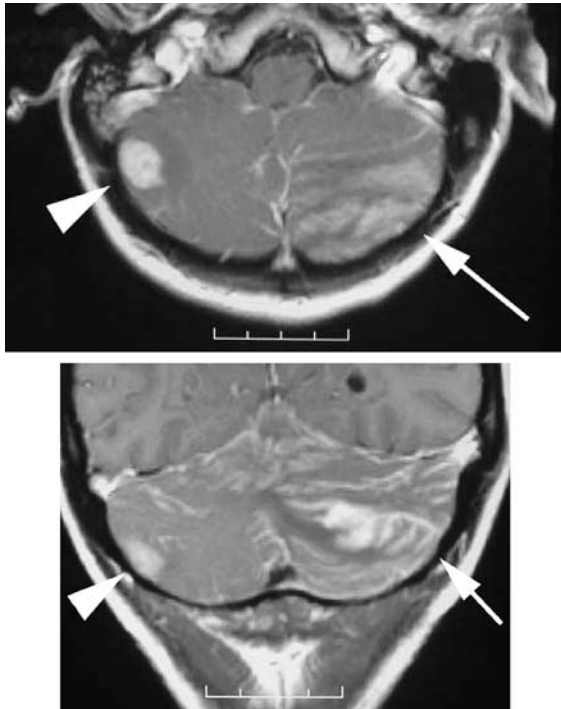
Axial and coronal brain MRI with gadolinium enhancement at time of presentation. Axial image: Wide arrow indicates homogeneously enhancing right superficial lateral cerebellar hemisphere lesion (1.6 cm in diameter) without apparent adjacent edema. Skinny arrow indicates irregularly shaped superior left cerebellar hemisphere enhancing lesion (1.4 cm in diameter) with associated edema. Coronal image: Arrows indicate leptomenigeal enhancement on the surface of both superior hemispheres.
